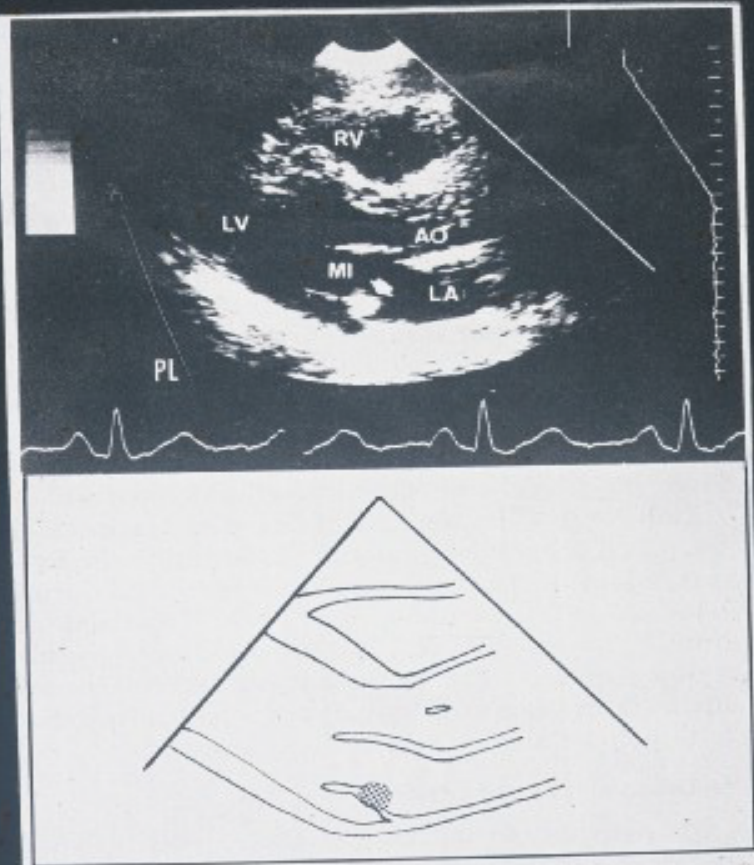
Long-Axis Parasternal (PL) Two-Dimensional Echocardiogram of a Patient with Libman-Sacks Endocarditis. A large vegetation can be seen on the posterior mitral leaflet (arrow). RV denotes right ventricle, LV left ventricle, AO aortic valve, MI mitral valve, and LA left atrium.
